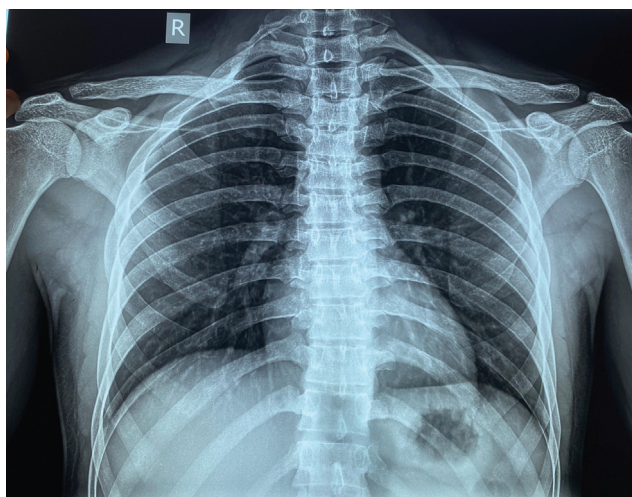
Chest X-ray of Case 2 showing cervical rib.
